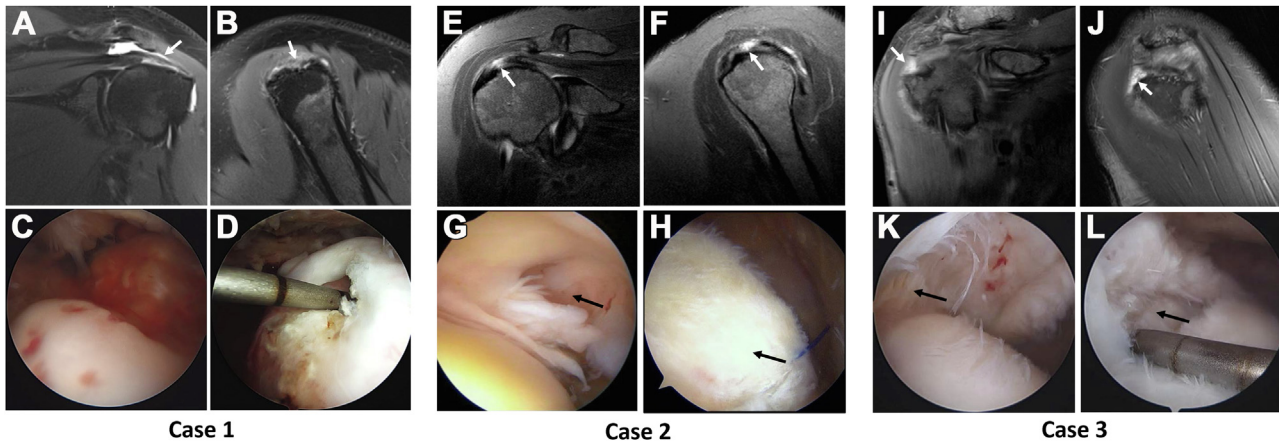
Examples of discrepant MRI and intraoperative tear grades. Case 1 (A-D): Both MRI readers independently graded this intraoperatively confirmed full-thickness tear as partial thickness. Coronal (A) and sagittal (B) MR images show severe thinning of the supraspinatus (arrows) but no apparent fluid gap to indicate a full-thickness tear. Arthroscopic photos from the articular (C) and bursal (D) views show the full-thickness tear. Case 2 (E-H): Both MRI readers independently graded this intraoperatively confirmed partial-thickness (articular-sided) tear as a full-thickness tear on MRI. Coronal (E) and sagittal (F) MR images demonstrate focal fluid-like signal (arrows), widest on the bursal side, crossing the thickness of the supraspinatus tendon. Arthroscopic photographs from the articular (G) and bursal (H) views show only a partial-thickness articular-sided tear was present (arrows indicate intact bursal fibers). Case 3 (I-L): Another intraoperatively confirmed partial-thickness (bursal-sided) tear that both readers independently graded as a full-thickness tear on MRI. Coronal (I) and sagittal (J) MR images demonstrate focal fluid-like signal crossing the full thickness of the supraspinatus tendon (arrows). Arthroscopic photographs from the articular (K) and bursal (L) views show only a partial-thickness bursal-sided tear (arrows indicate intact articular fibers). MRI, magnetic resonance imaging.
